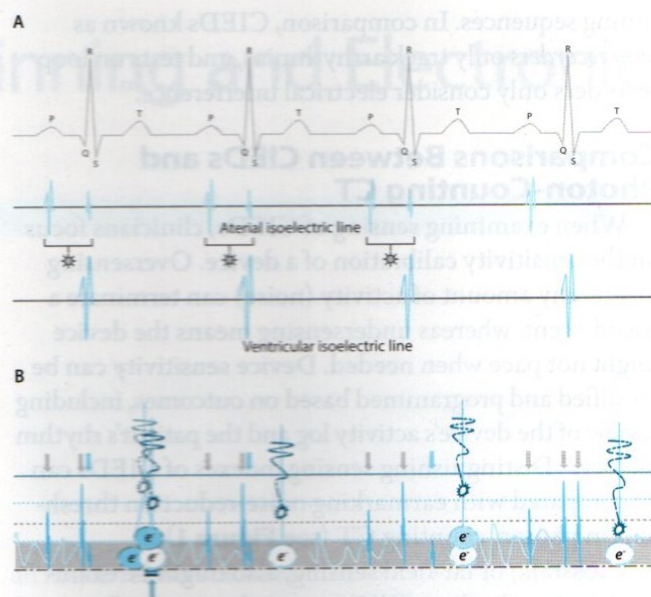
A. CIED electrogram showing sinus rhythm (top line) and far-field sensing (asterisks) in the atrial lead from ventricular activity. Although far-field sensing disrupts a device's atrial timing sequence, it can be rectified by adjusting the blanking period associated with the atrial lead. Blanking denotes a period after atrial sensing in which subsequent activity is invisible to the CIED. Blanking periods are similar to absolute refractory periods associated with cardiac and skeletal muscle. B. Charge sharing of electrons (e^-) compared with information from in-line trajectories on sectional view of a direct conversion CT photon-counting detector. Charge sharing (blue e^-) degrades image quality. Corrections for electron sharing of charge between adjacent detector pixels involve communication between the pixels, such that summation of activity gets attributed to the detector pixel collecting the most charge (up arrow). Images courtesy of the author.
